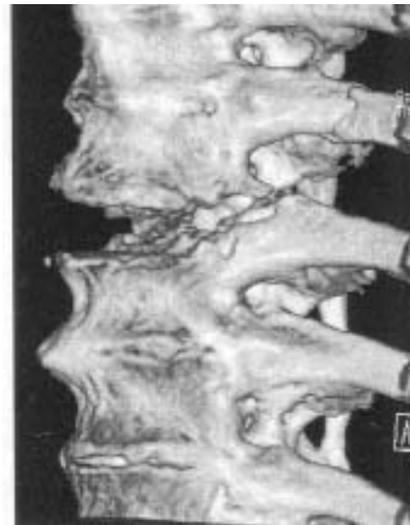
3-D computed tomographic reconstruction of the thoracic spine, lateral projection, showing the three column injury.
